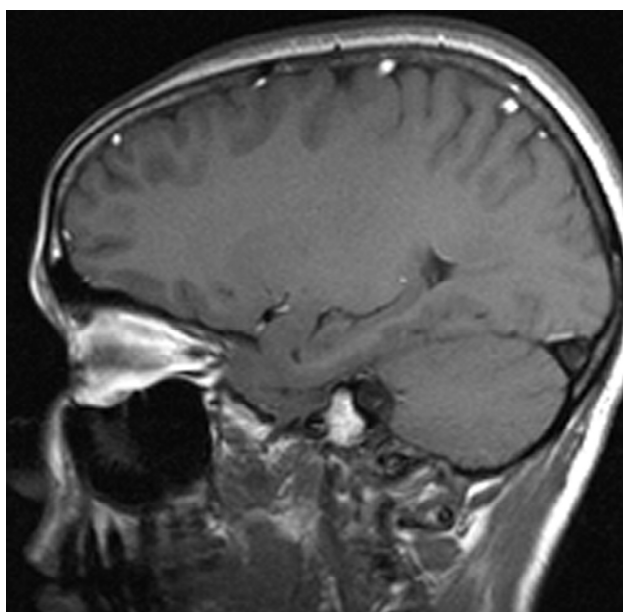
MRI of brain showing no change in the size and density of the tumour with medical management after two weeks.
